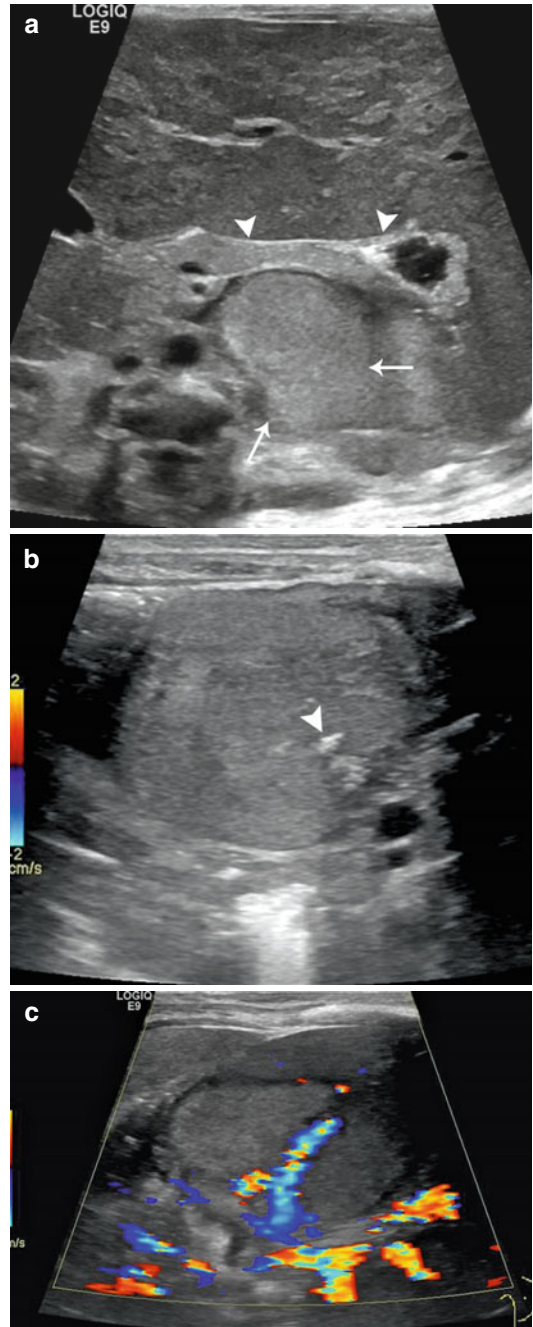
Neuroblastoma – US. Transverse ultrasound image of the upper abdomen (a) in this neonate reveals a solid-appearing mass arising from the left adrenal gland (arrows) which displaces the pancreas (arrowhead) anteriorly. On focused ultrasound image (b) the left adrenal mass contains echogenic foci (arrowheads) due to calcifications. Color Doppler image of the left adrenal mass (c) demonstrates internal vascularity (arrow) unlike the appearance of an adrenal hemorrhage (See Fig. 16.8)
